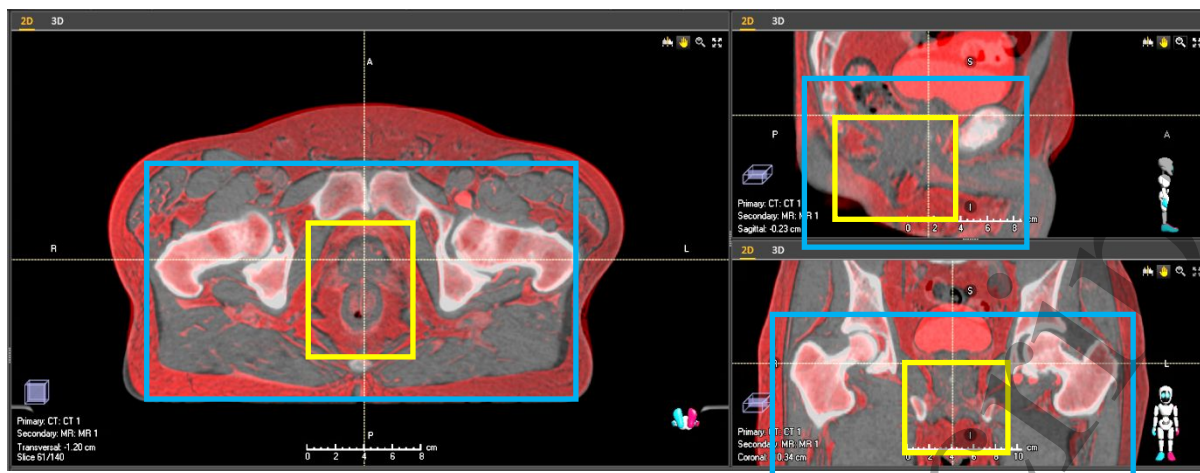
Local RIR for a patient with a prostate carcinoma. Grey overlay images are CT and red overlay images are MRI. The recommended guiding ROIs used for the initial bony based and final soft tissue local registrations are shown in blue and yellow respectively.
